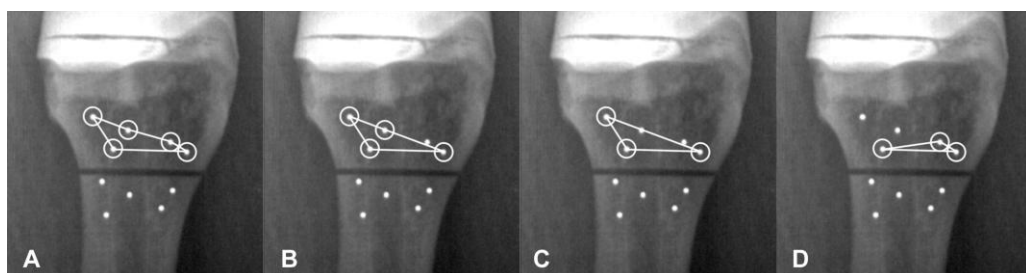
Anteroposterior radiographs showing the four different marker configurations used to define the distal rigid body segment (figure from Study II).
